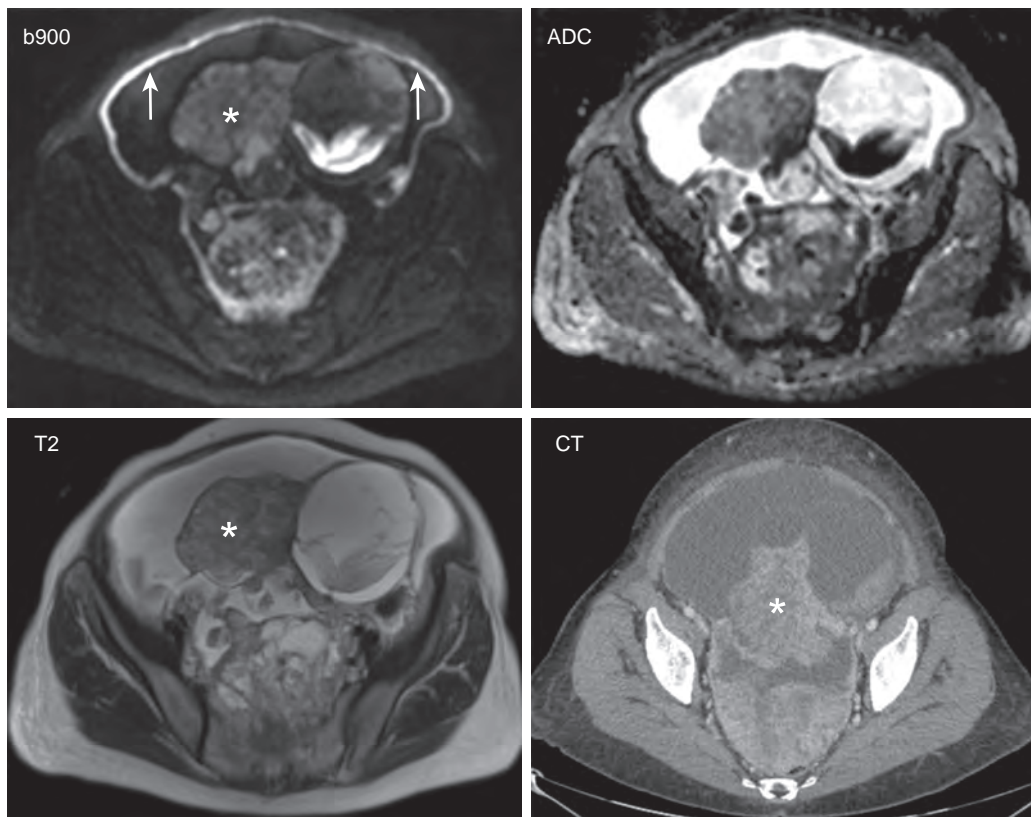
A 52-year-old woman with ovarian carcinoma and peritoneal carcinomatosis. The high- b value diffusion-weighted image (b900) shows excellent contrast between the hyperintense tumor coating the peritoneal lining (arrows) and ascites in the pelvis, which is almost completely attenuated in signal. The large primary ovarian mass (*) is also seen on the b900 image. In comparison, the true extent of peritoneal disease is easily underestimated on morphologic T2-weighted and computed tomography (CT) images. ADC, Apparent diffusion coefficient.
